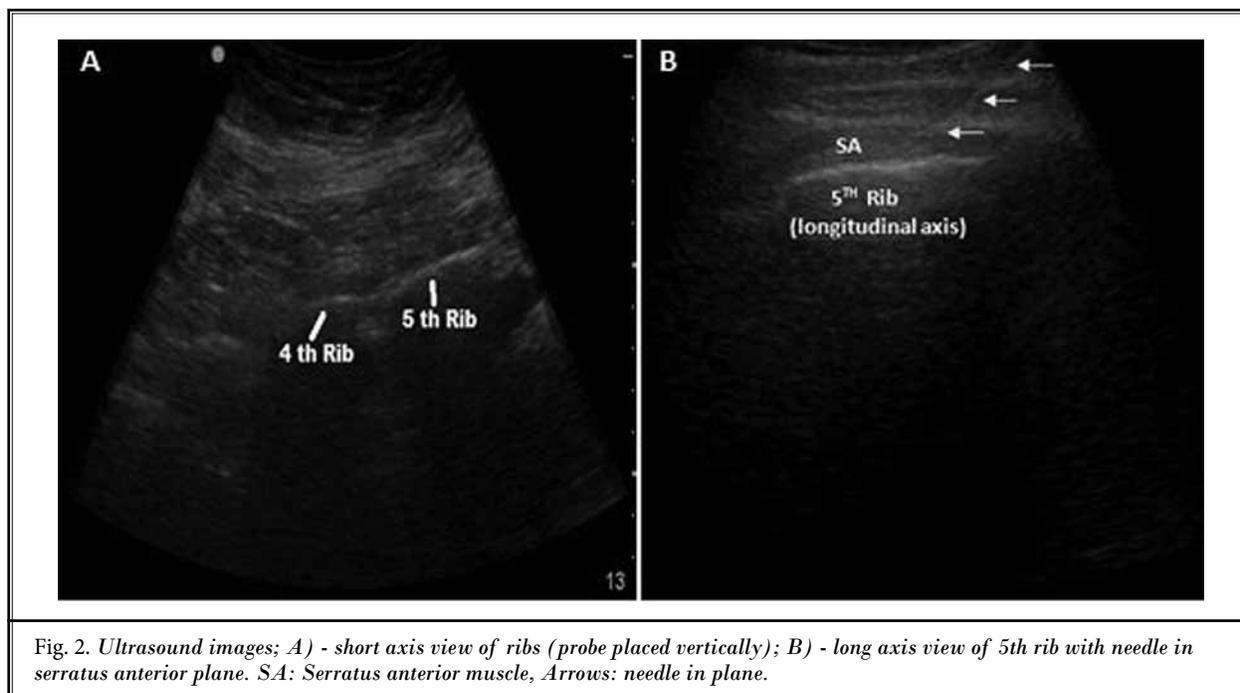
Ultrasound images; A) - short axis view of ribs (probe placed vertically); B) - long axis view of 5th rib with needle in serratus anterior plane. SA: Serratus anterior muscle, Arrows: needle in plane.
